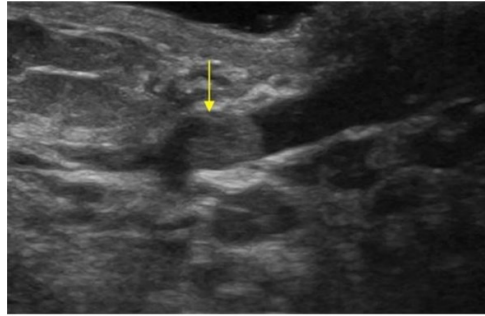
Sample ultrasound images representing different types of fibroadenomas.
